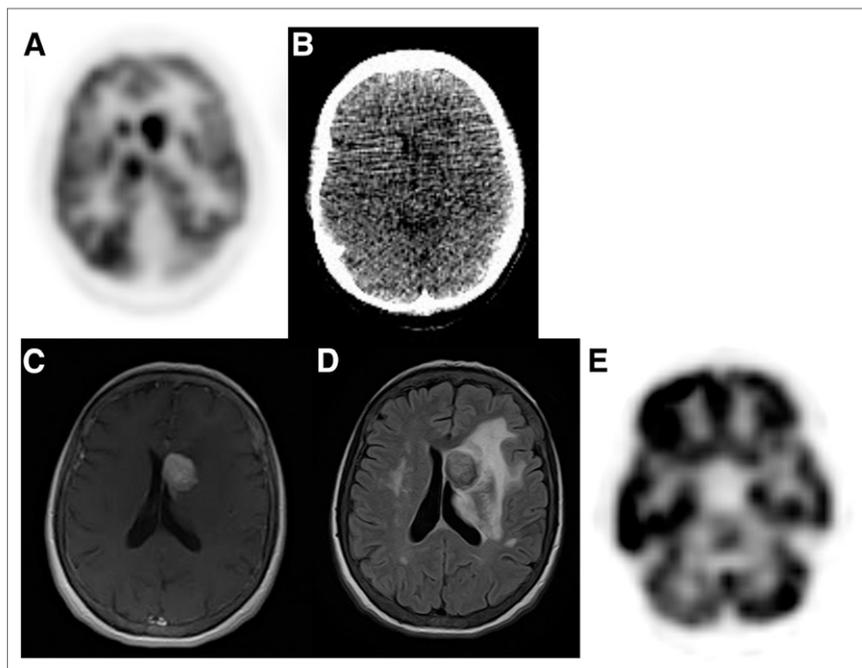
(A and B) Axial ^{18}F -FDG PET and low-dose CT images of brain demonstrate hypermetabolic lesion in left caudate. (C) Subsequent contrast-enhanced axial MRI of brain confirmed metastasis. (D) Axial T2 FLAIR imaging demonstrates surrounding vasogenic edema. (E) PET also shows crossed-cerebellar diaschisis with decreased activity in contralateral right cerebellum.
